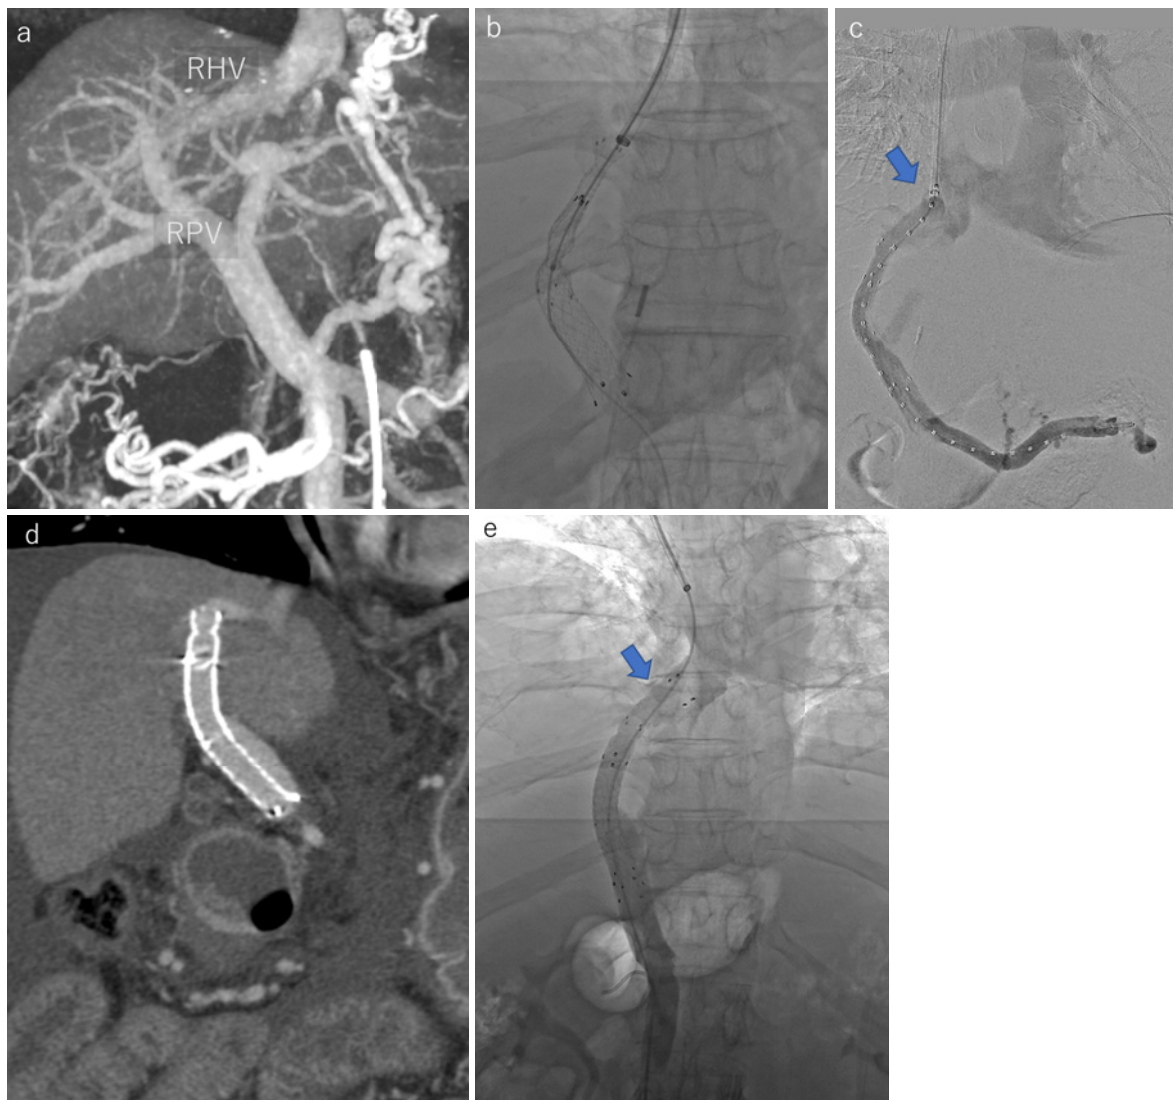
A 70-year-old male with a history of alcoholic cirrhosis, presenting with refractory ascites. (a) Contrast-enhanced computed tomography MIP image shows the location of the right hepatic vein (RHV) and right portal vein (RPV). (b) Viabahn (W.L. Gore & Associates, Phoenix, AZ, USA) (10 mm) within the liver parenchymal tract and Luminexx (BARD, Murray Hill, NJ) (10 mm) within the portal vein. (c) Spleno-venogram reveals incomplete stent extension at the hepatic venous end, resulting in stenosis (arrow). (d) Contrast-enhanced computed tomography coronal image shows that the covered stent is positioned toward the RHV. (e) Resolution of stenosis is seen after shunt extension into the proximal part of the RHV with an additional bare metal stent.
